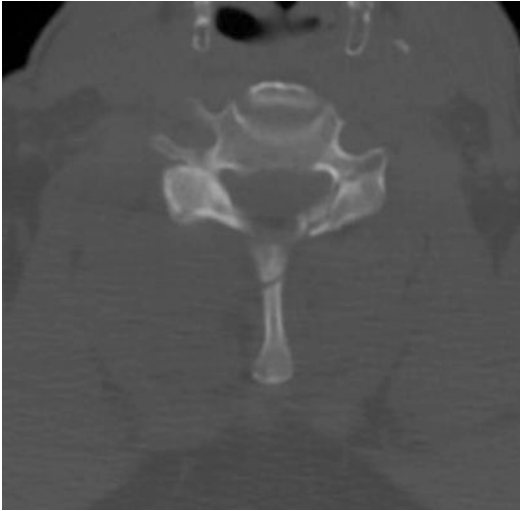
CT image demonstrating a spinous process fracture in the cervical spine
